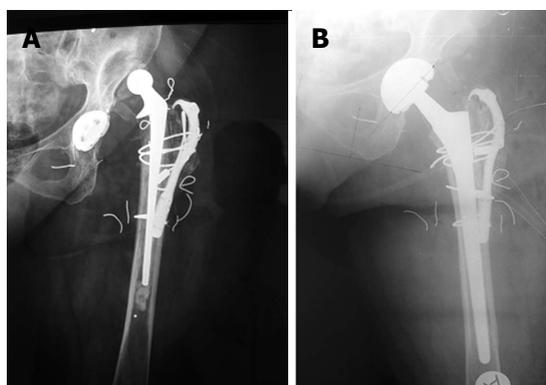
Modular stems. A: Preoperative anteroposterior (AP) radiograph of a dislocated left hip with a Paprosky type IIIA defect; B: Postoperative AP radiograph of the revised hip with a modular stem.
